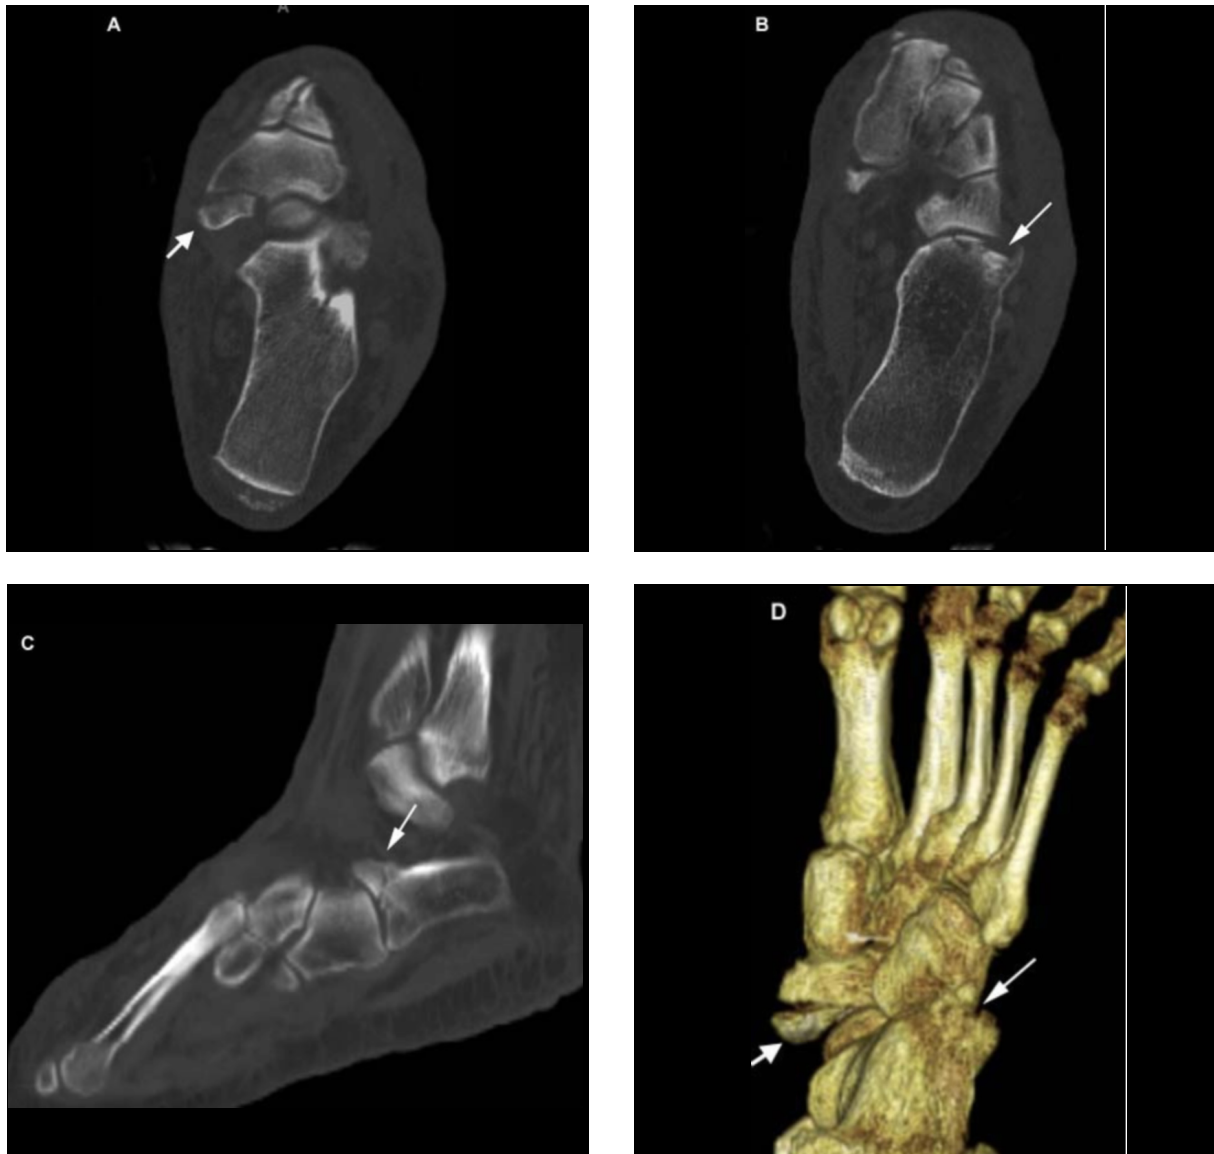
Axial CT of the right foot (A, B) with sagittal (C) and 3-D (D) reformations. Navicular avulsion fracture (wide arrows) and depressed intra-articular fracture of the calcaneus at the calcaneocuboid joint (narrow arrows) are noted.
